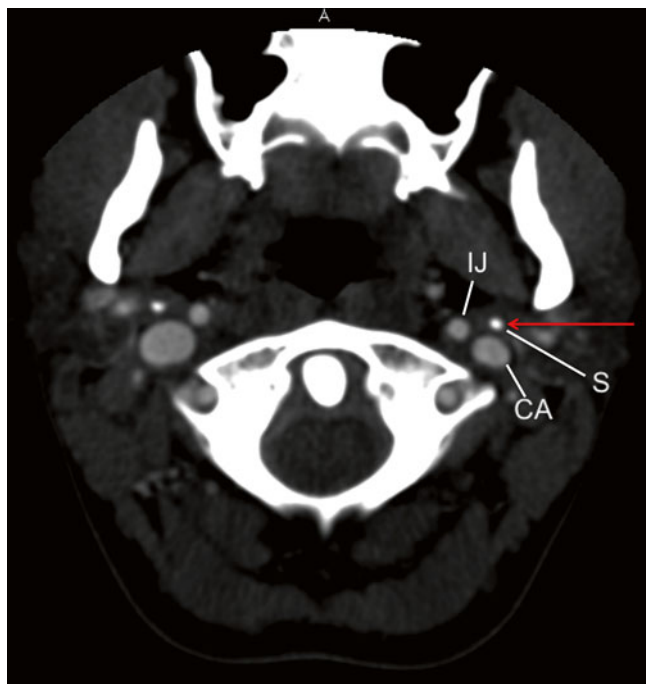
Axial CT image with contrast at the level of the styloid. *IJ* internal jugular vein, *CA* carotid artery, *S* styloid. The *red arrow* represents the proposed injection path (Image courtesy of Andrea Trescot, MD)
